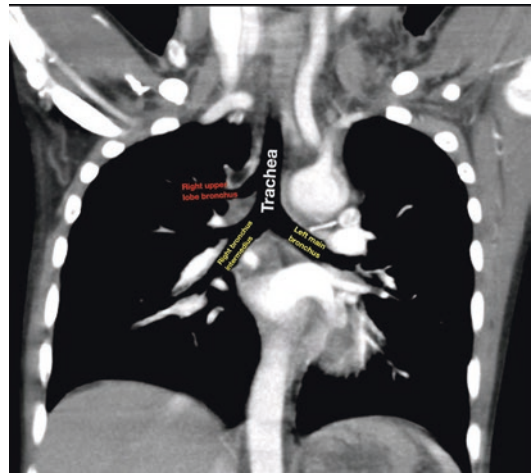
Coronal section of computed tomography scan of chest showing tracheal bronchus (the right upper lobe bronchus originates directly from the supra-carinal trachea)
